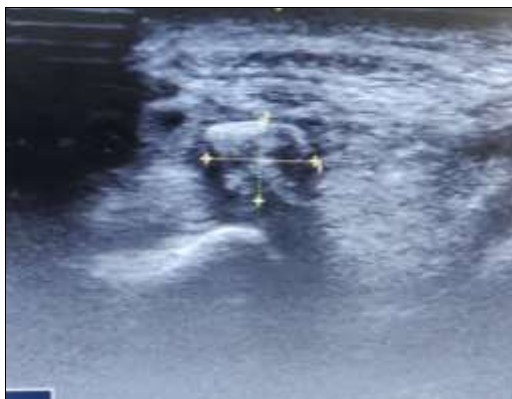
Ultrasound showing echogenic lesions suggestive of calcification at triceps insertion.
